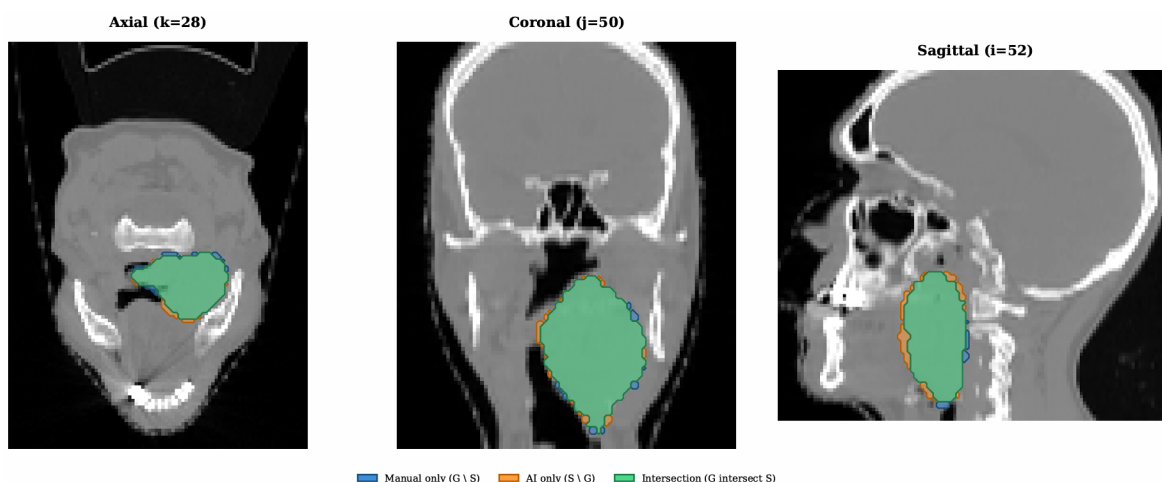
GTV mask union overlaid on the CT, patient HN_0717: manual-only (blue), AI-only (orange), intersection (green).
